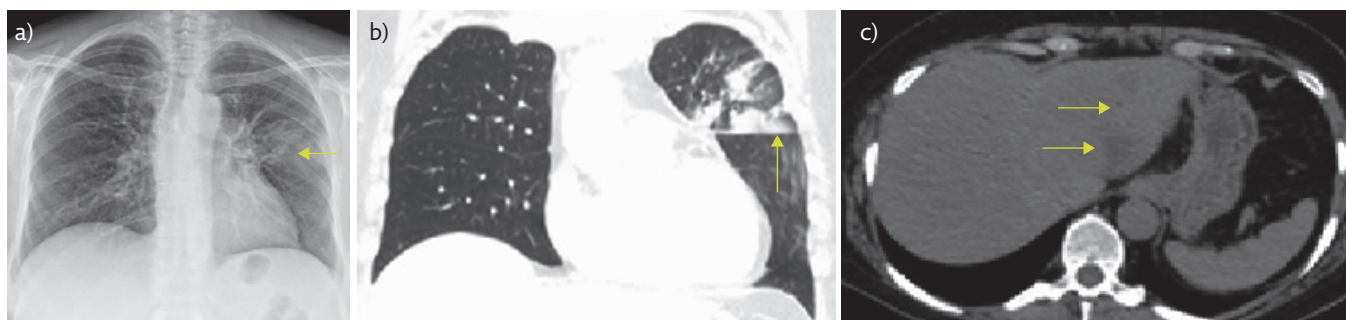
a) Chest radiography and b) chest CT showed a tumour mass (arrows). c) Abdominal CT, without contrast because the patient got an allergic rash after a chest CT, so next CTs were with pre-medication. Arrows indicate multiple hepatic metastases. Images from April 2018.
